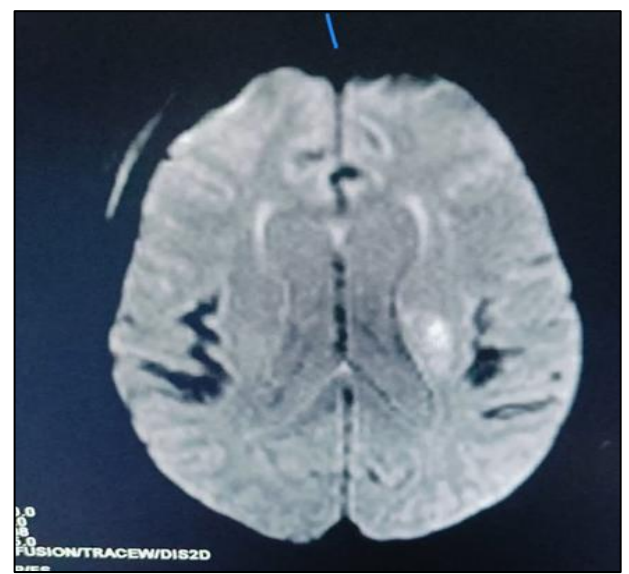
MRI brain DWI Acute infarct over left MCA territory.
